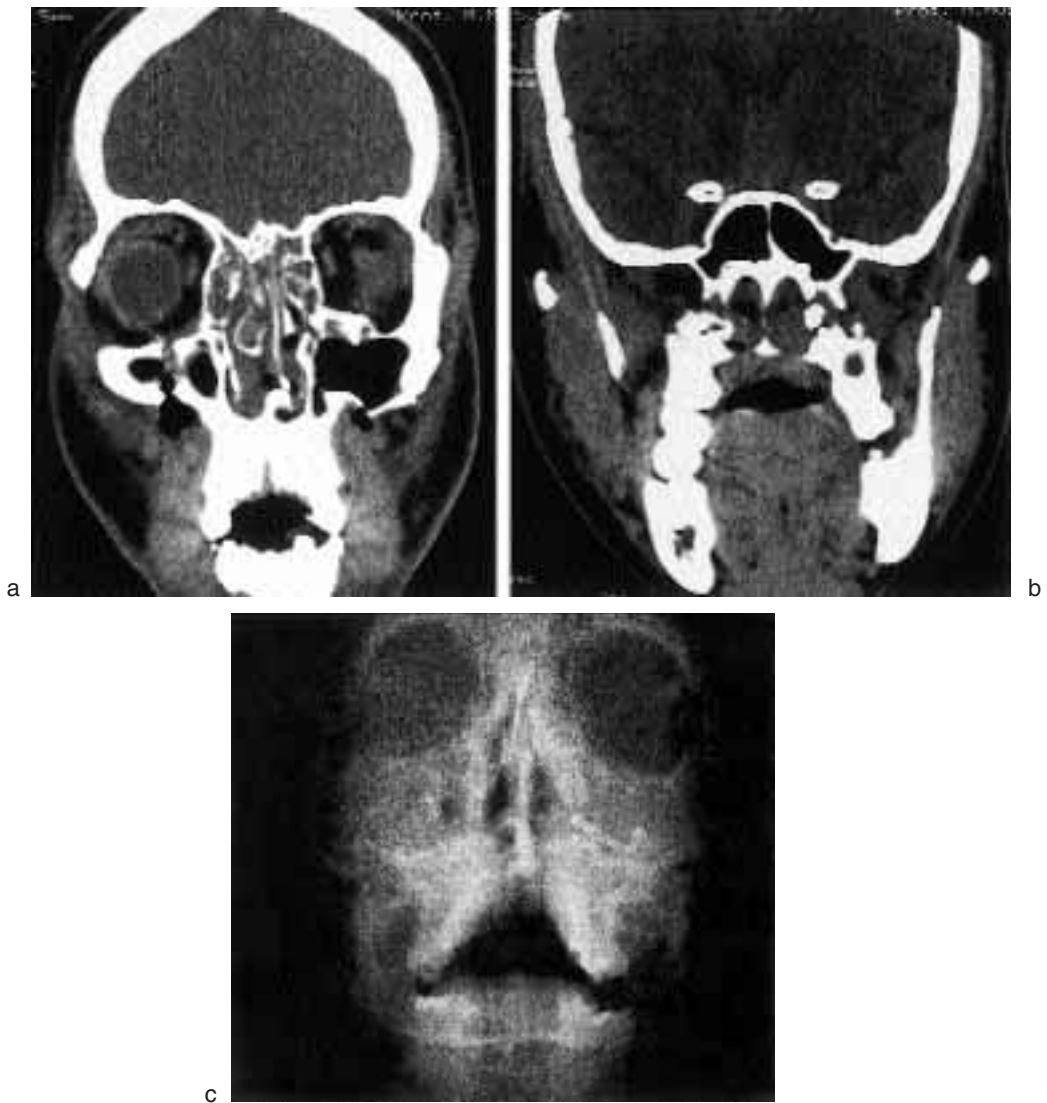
Pre-operative coronal CT of a LeFort type II fracture. Reduction and fixation with 3 mini-plates (c).
